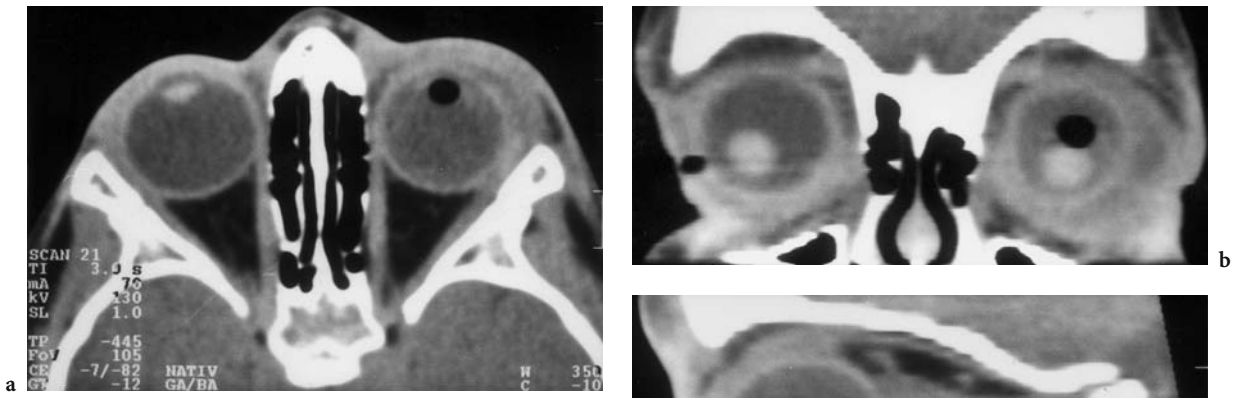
A 2-year-old boy with orbital contusion caused by an exploding bottle. Diagnosis: perforation and collapse of the globe with luxation of the lens. HR-CT: a Axial view; although no foreign body is detectable, an air bubble posterior to and at the level of the lens of the left eye can be identified. Coronal (b) and sagittal (c) reconstruction with caudal dislocation of the lens
